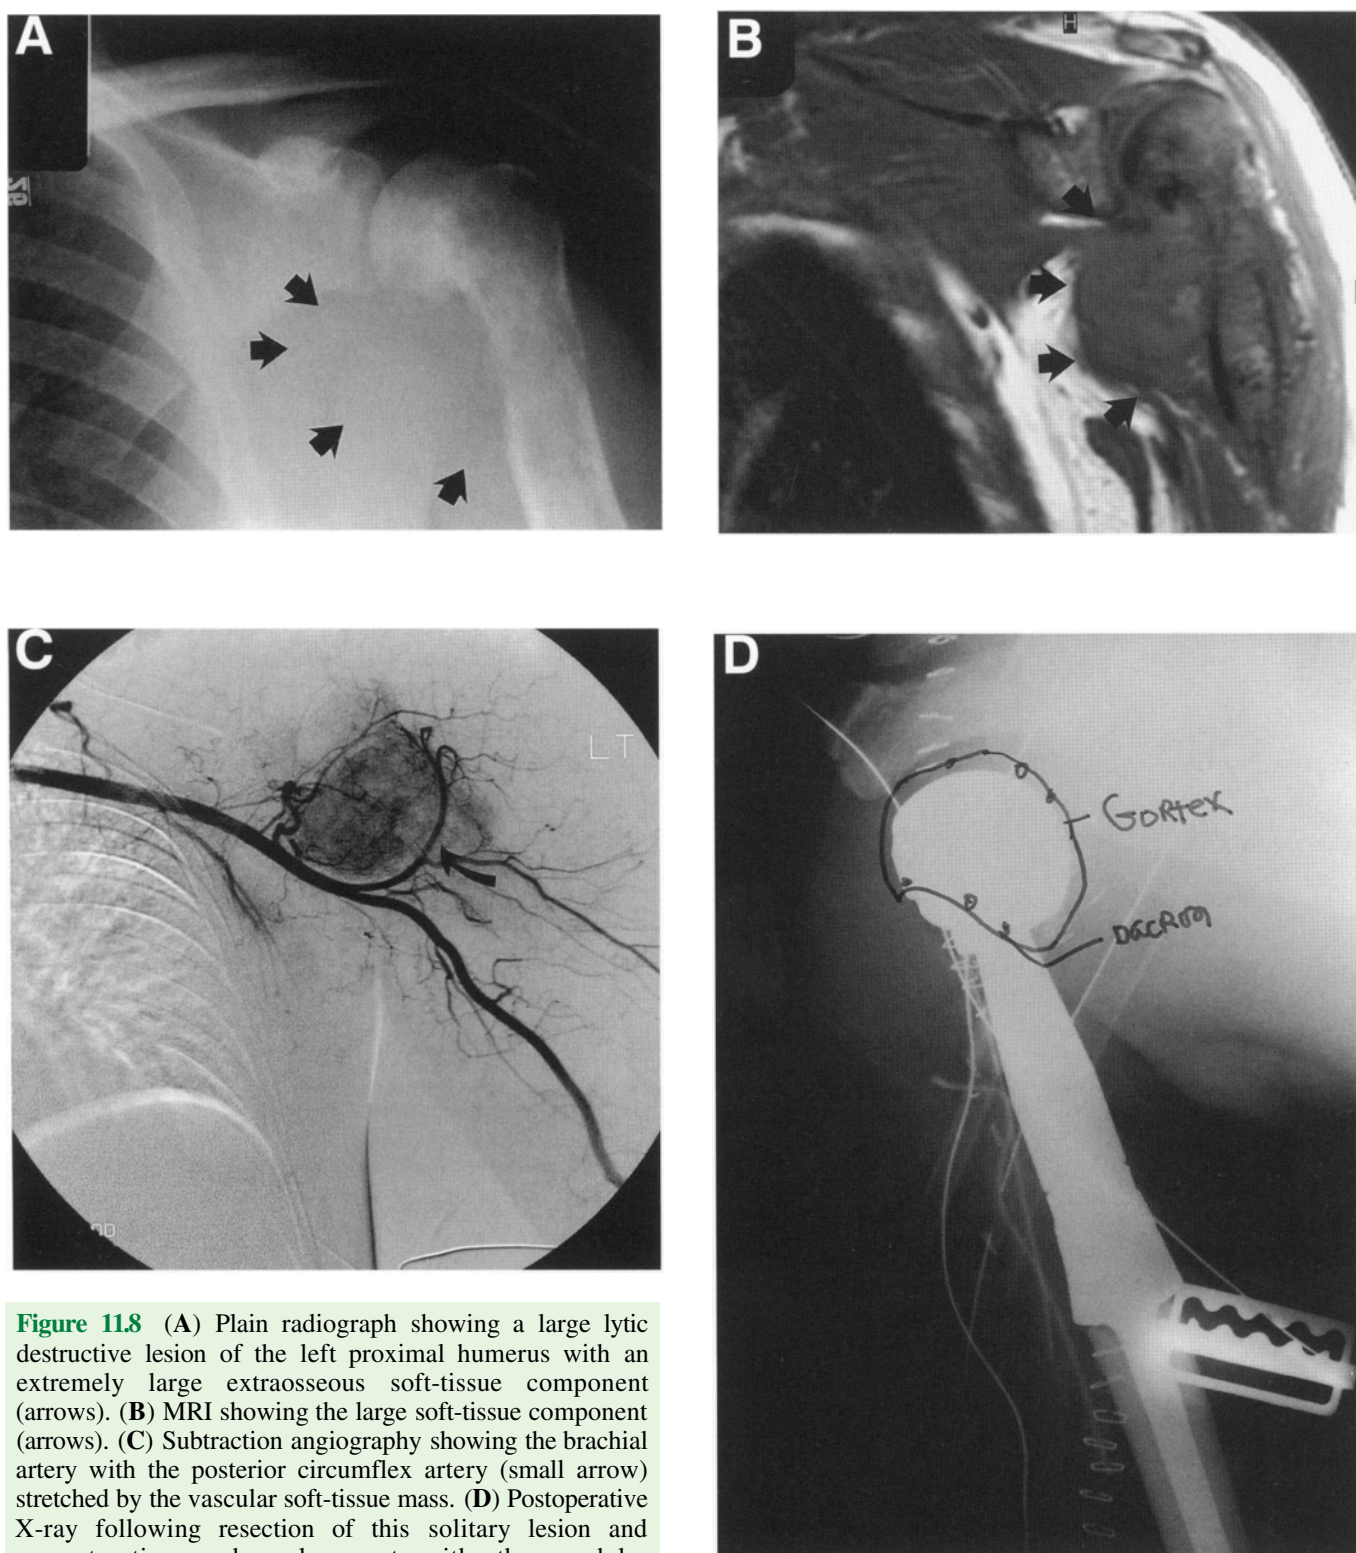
(A) Plain radiograph showing a large lytic destructive lesion of the left proximal humerus with an extremely large extraosseous soft-tissue component (arrows). (B) MRI showing the large soft-tissue component (arrows). (C) Subtraction angiography showing the brachial artery with the posterior circumflex artery (small arrow) stretched by the vascular soft-tissue mass. (D) Postoperative X-ray following resection of this solitary lesion and reconstruction and replacement with the modular segmental replacement prosthesis. Note: Gore-Tex[®] graft is utilized to stabilize the humeral head, neck, and glenoid joint. The Gore-Tex[®] is reinforced by Dacron tape as noted. Large solitary metastatic tumors to the skeletal system with large extraosseous components are best treated by primary resection.
